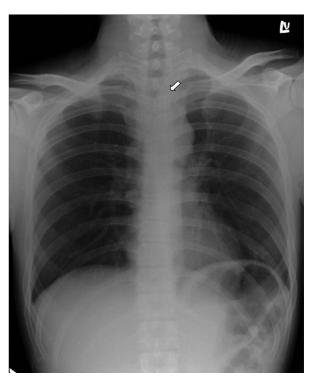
Plain chest radiograph showing a foreign body within the esophagus.
